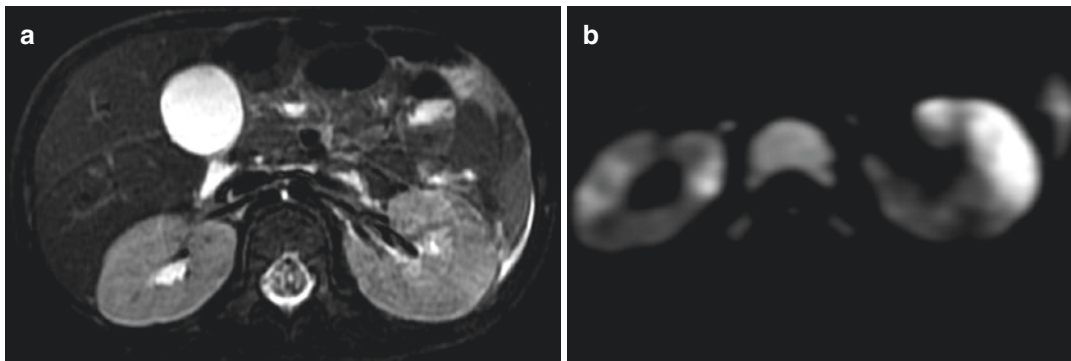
Bilateral pyelonephritis at MR imaging. Axial T2-W image (a) shows an enlarged left kidney without salient signal anomaly. Axial DWI image (b) depicts
